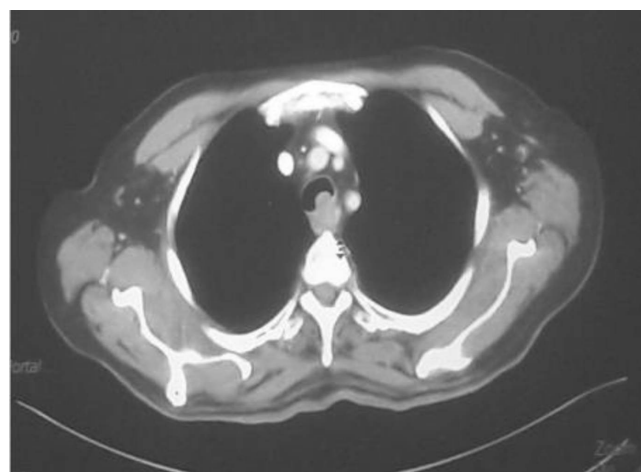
Axial cut of CT thorax in mediastinal window. A round, enhancing mass in the trachea is seen with no evidence of mediastinal lymphadenopathy
